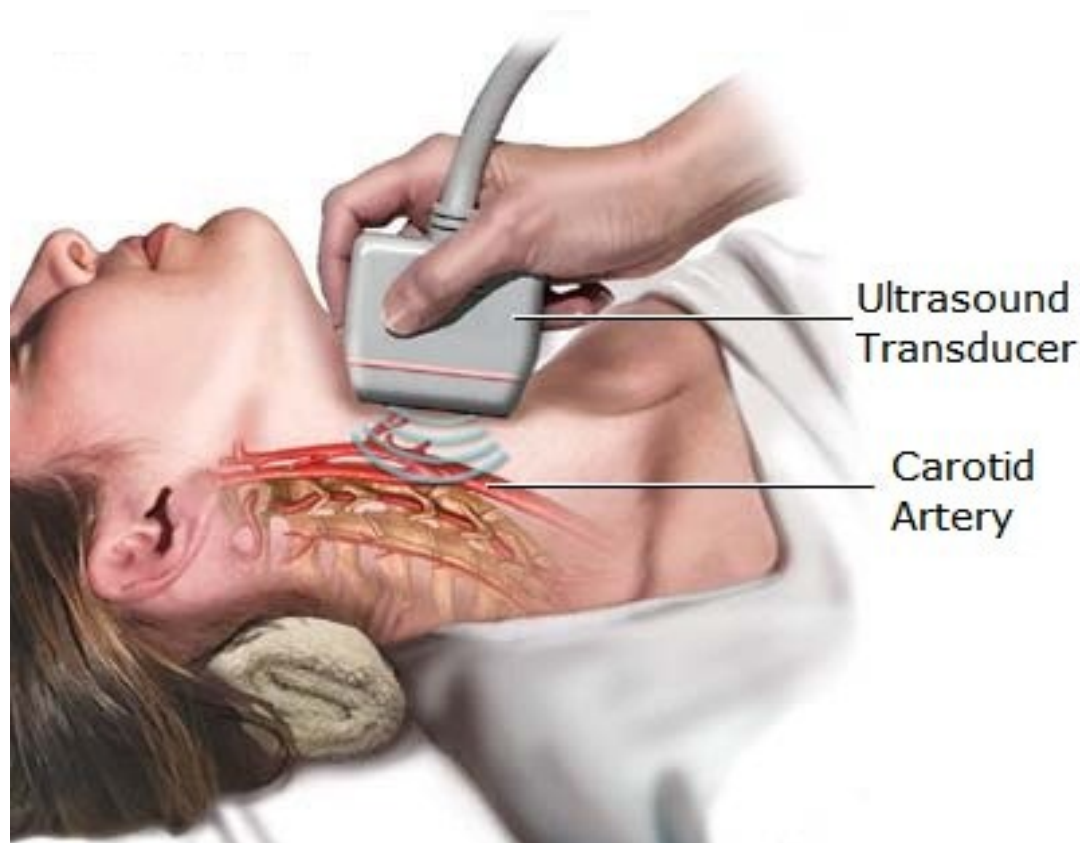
Reprinted from AllRefer website. An example of carotid ultrasound scan. An ultrasound transducer is placed over the suspect arteries in the neck, and information about the vessel's blood flow is collected. (AllRefer 2012)
